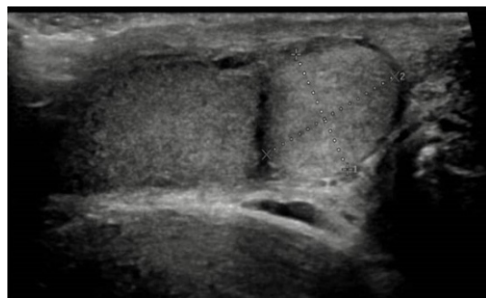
A gray scale ultrasound image of the right extra testicular mass and the testis
